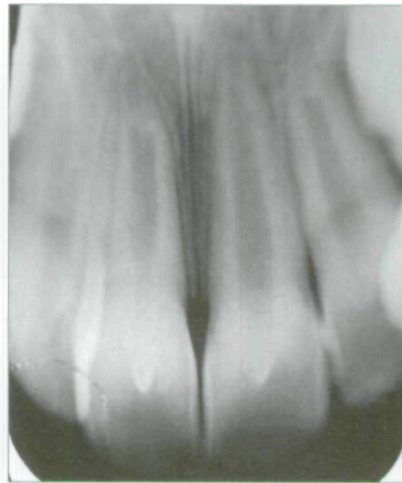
Intraoral periapical radiograph taken 18 months following treatment.
